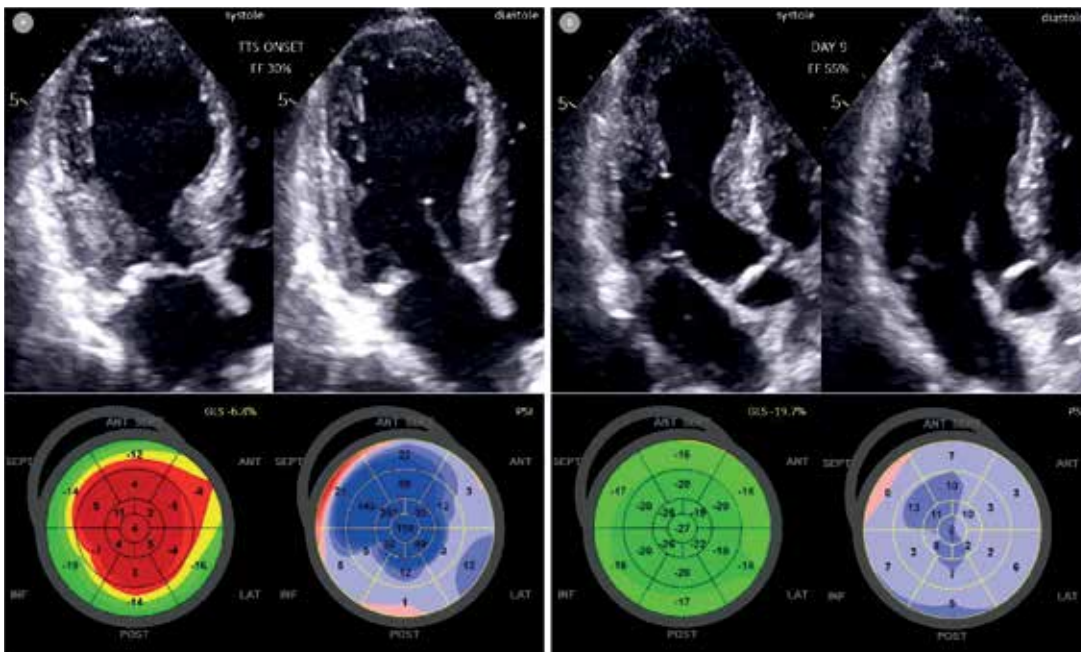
Echocardiography at TTS onset and 9 days after: left ventricle in systole and diastole in apical long axis view; global and segmental longitudinal strain (red/yellow/green bull's eye map), segmental post-systolic index (blue/red bull's eye map)
